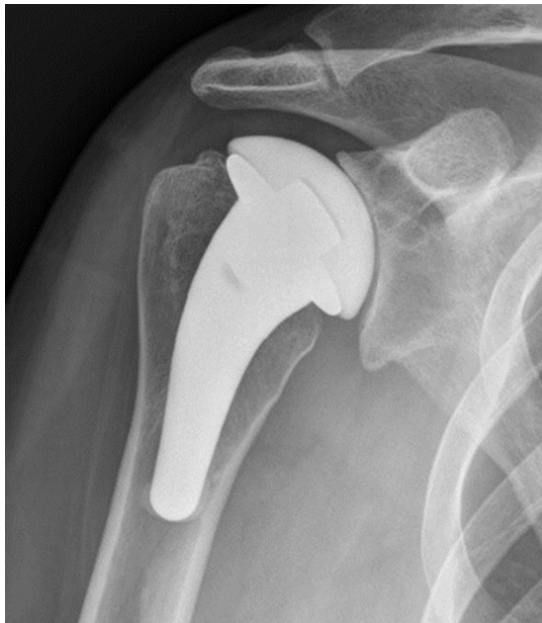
An X-ray image of a pyrocarbon hemiarthroplasty implant.
